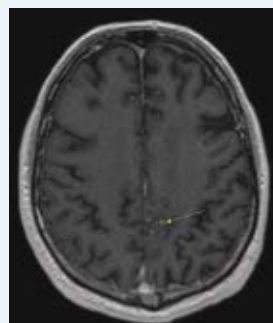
MRI with contrast taken 6.5 years after ablation showing a single speck of enhancement (arrow) and no clear evidence of residual or recurrent tumor. The patient has remained asymptomatic.
